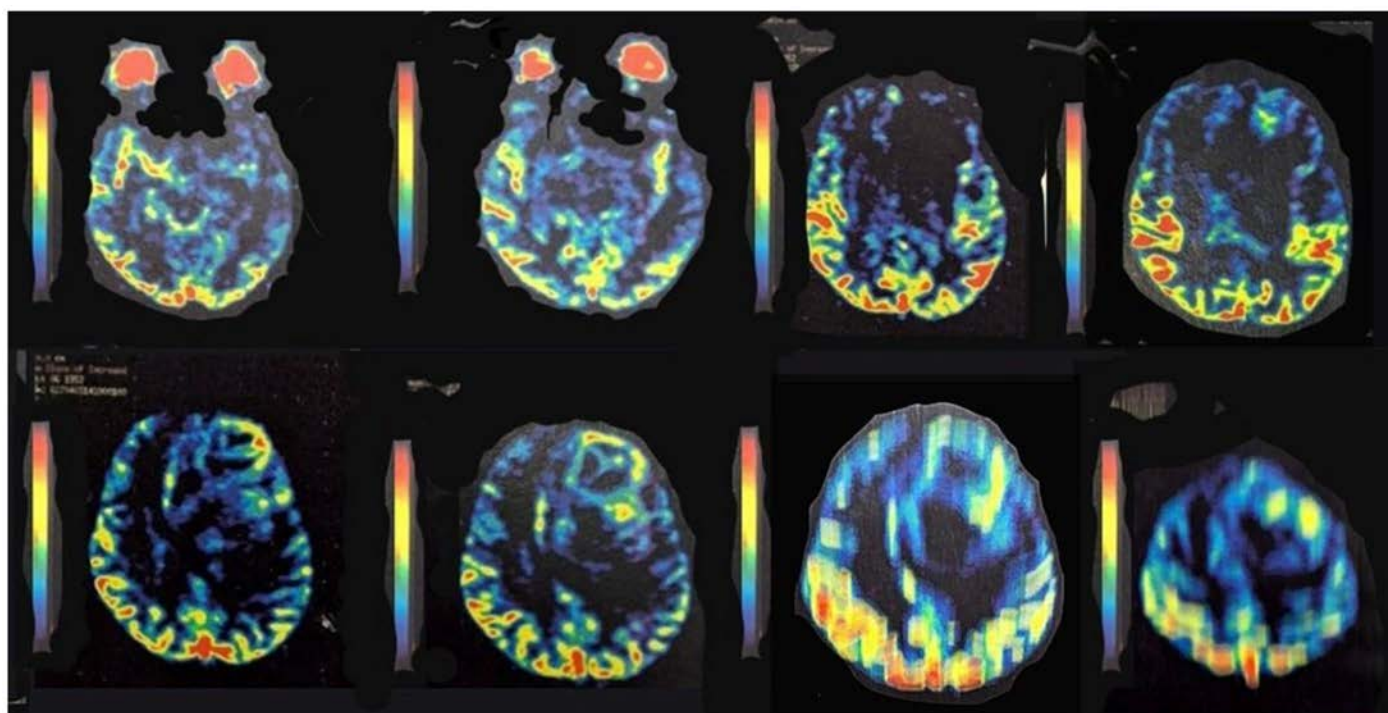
MRI with Perfusion Study using the ASL (Arterial Spin Labeling) technique, which eliminates the need for exogenous contrast injection. The study shows uptake with a pattern of high metabolic activity, with a low signal center (necrosis), as well as subcortical expansion, characterizing the high aggressiveness of the lesion in the white matter.
